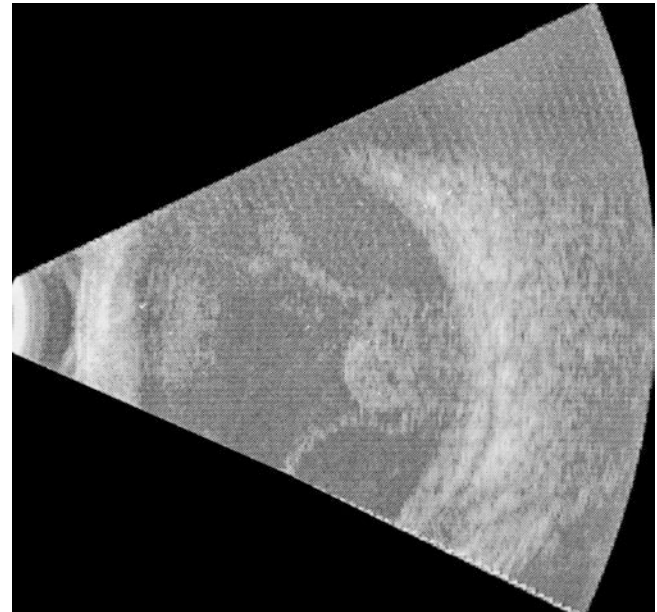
Ocular ultrasonography of a patient with a massive choroidal tubercular granuloma with choroidal detachment
